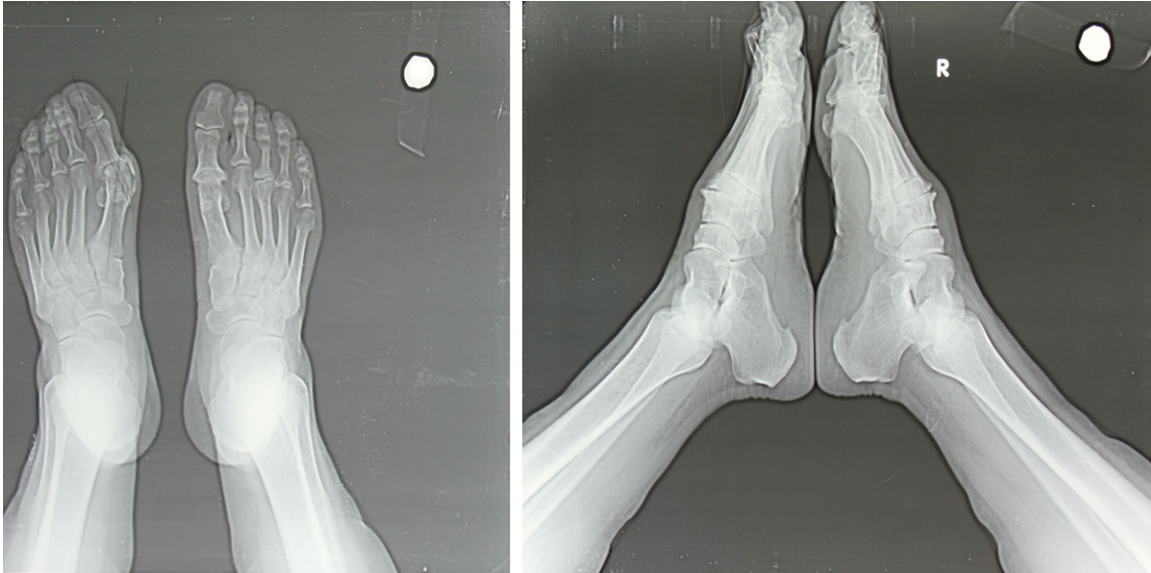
Preoperative AP and lateral foot X-Rays of a 65-year-old female patient; there is history of Right foot first toe distal metatarsal osteotomy 11 years ago. There are symptoms of recurrent Hallux valgus and joint arthrosis.
